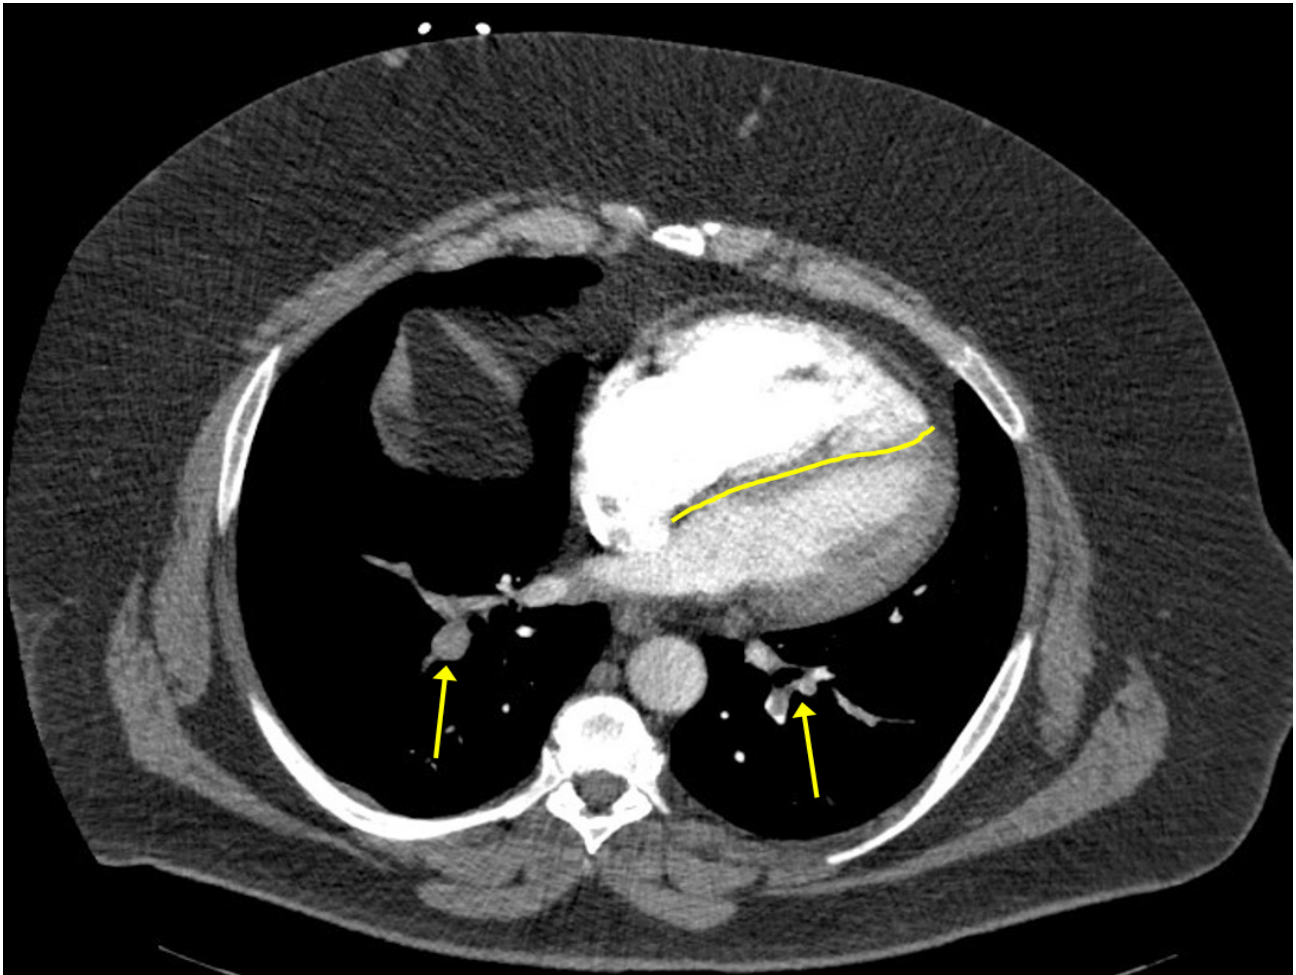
Additional view of the computed tomography pulmonary angiogram demonstrating occlusive and nonocclusive lower lobe pulmonary artery emboli bilaterally (yellow arrows). Straightening and leftward bowing (yellow line) of the interventricular septum indicating right-sided heart strain is also visible.
